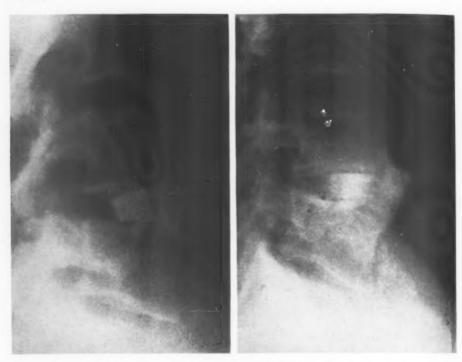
(a) Lat X-ray for position of bone implantation 30 days postoperative. (b) Lat X-ray for progress 11 mos. postoperative. Fusion present.
